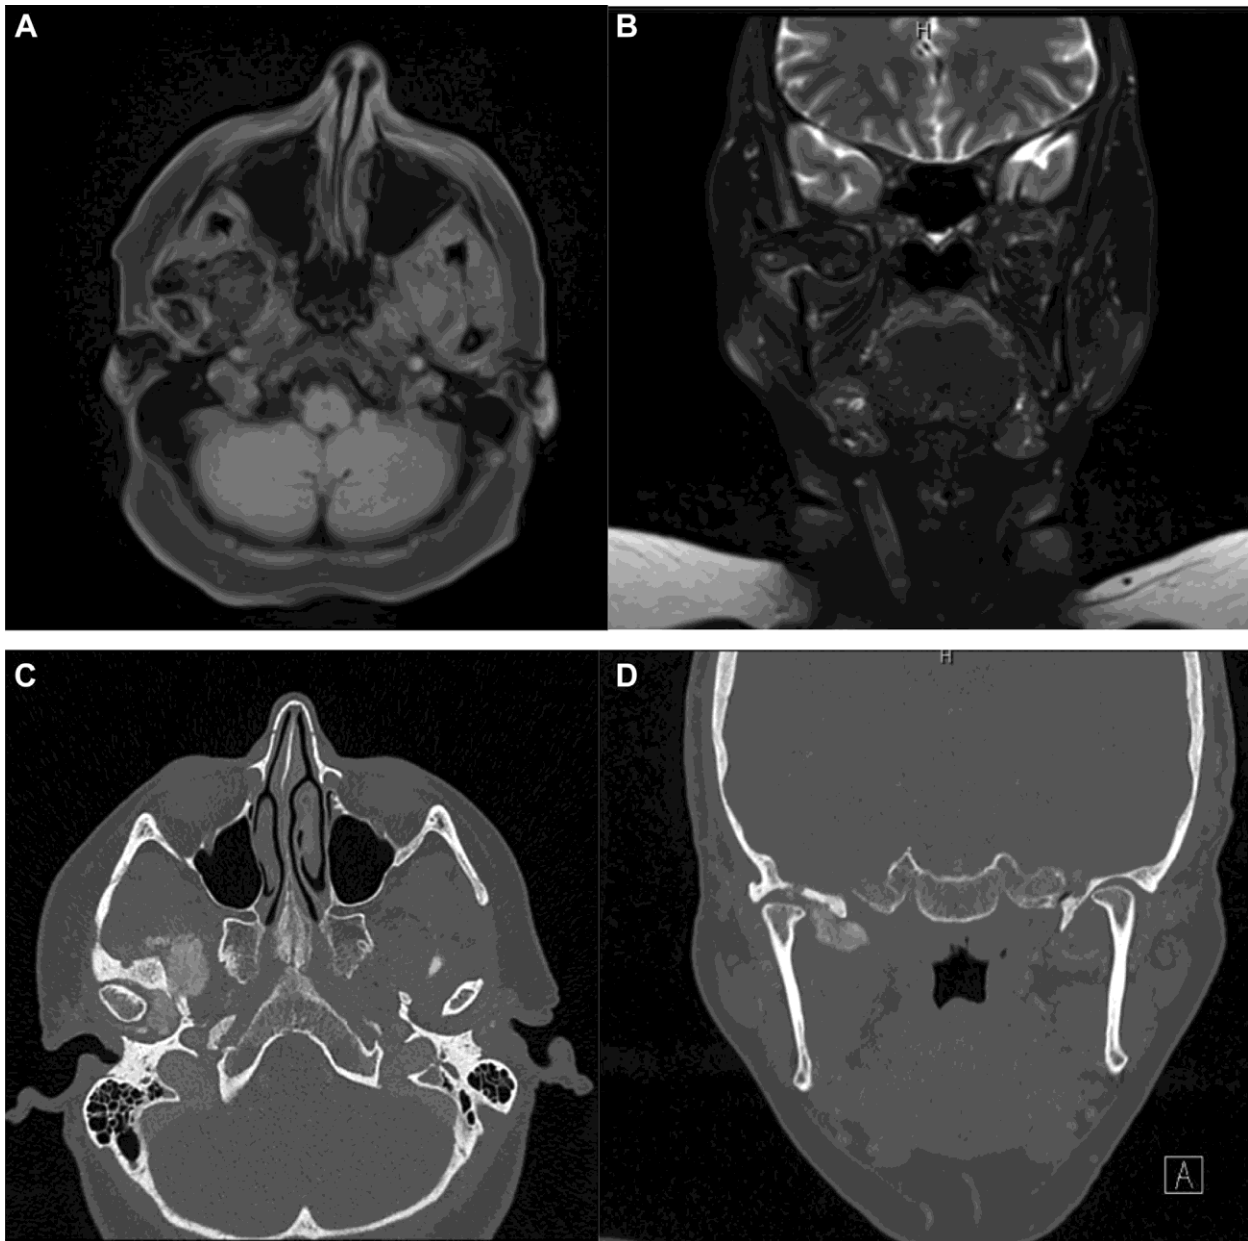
A, and B, Pigmented villonodular synovitis (MRI). C, and D, Pigmented villonodular synovitis (CT).
